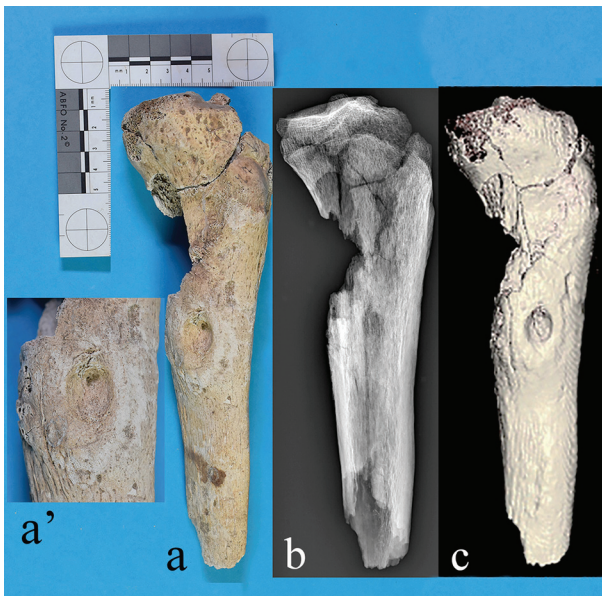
The tibia of subject Liut A. The proximal diaphysis is altered and enlarged by bone thickening due to a severe form of osteomyelitis. The presence of a circular depression with a diameter of about 21 mm at the point of maximum thickening represents a cloaca with signs of bone repair (a-a'). Computed Tomography (b) and 3D Computed Tomography reconstruction (c) highlight the 0.7 mm raised crateriform lesion, centrally depressed, with blunted edges.
